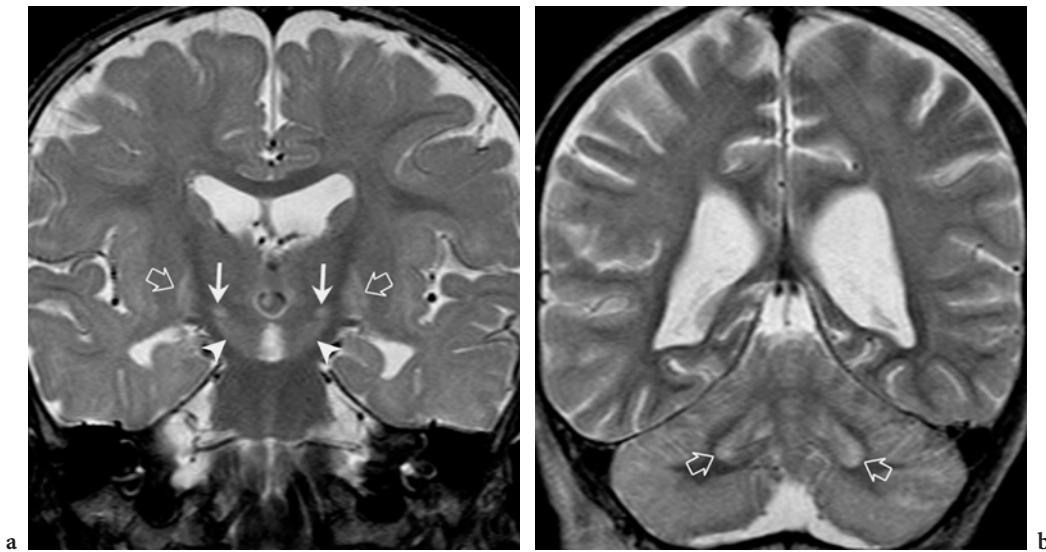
Optimal visualization of subthalamic and dentate nucleus lesions in the coronal plane in metabolic disorders. a Coronal T2-weighted fast spin-echo image in an 18-month-old male patient with history of prolonged postnatal hyperbilirubinemia, leading to kernicterus. The abnormal hyperintensity within the subthalamic nuclei (*thin arrows*), as well as the globi pallidi (*open arrows*) and the substantia nigra (*arrowheads*) is clearly demonstrated. b Coronal T2-weighted fast spin-echo image in a 9-year-old male patient with propionic acidemia after acute metabolic crisis. The abnormal hyperintense appearance of the dentate nuclei (*open arrows*) and of the cerebellar cortex is best appreciated in the coronal plane
